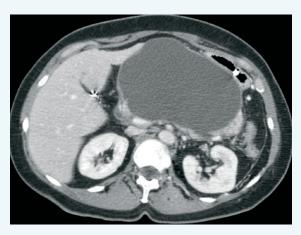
CT abdomen and pelvis demonstrating central pancreatic necrosis and large pseudocyst with mass effect on the stomach and proximal duodenum.
